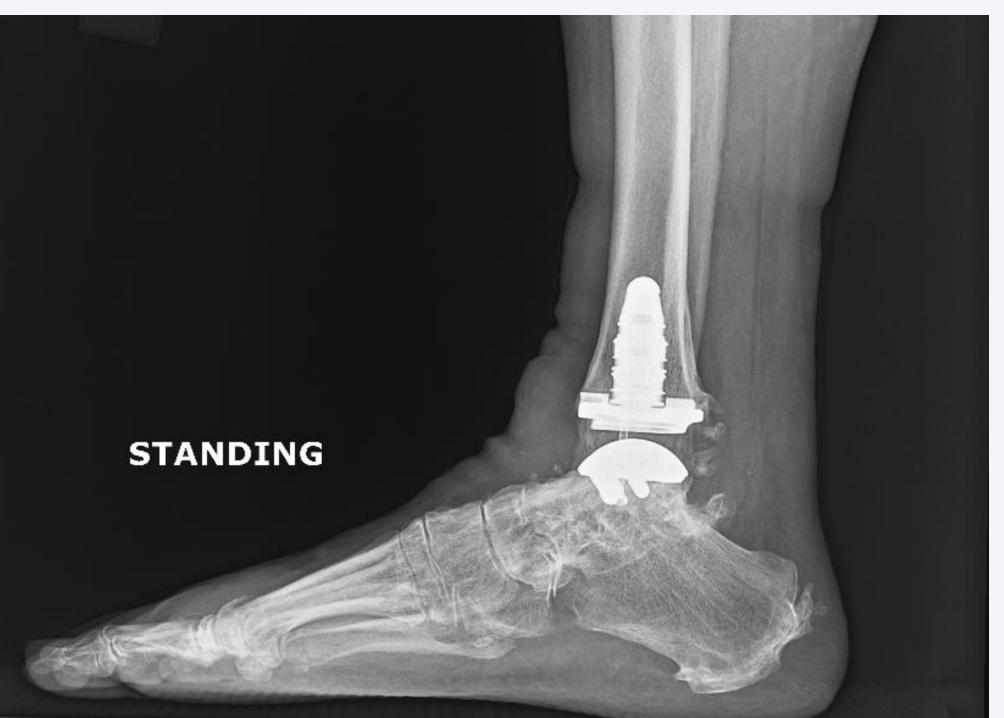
Pre-operative ankle radiograph and MRI demonstrating talar AVN, followed by index hindfoot arthrodesis, followed by TAA with prophylactic medial malleolar fixation
